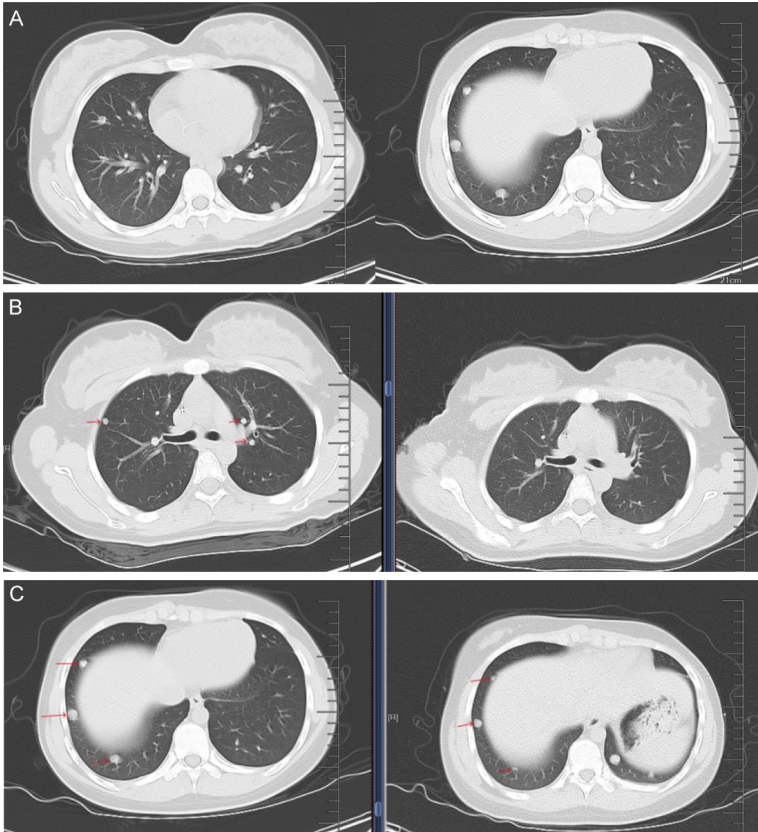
A. Chest CT scan at different levels revealed multiple nodules in the lungs, which were consistent with metastases. B. After two courses of adjuvant chemotherapy, the lung metastases had shrunk, with the largest nodule measuring approximately 0.8 cm and exhibiting clear edges. The nodules in the lungs, indicated with red arrows, had disappeared. Left panel: Chest CT scan taken on Feb 19, 2024. Right panel: Chest CT scan taken on Mar 15, 2024. C. The nodules in the lower lungs, noted with red arrows, had shrunk. Left panel: Chest CT scan taken on Feb 19, 2024. Right panel: Chest CT scan taken on Mar 15, 2024.
